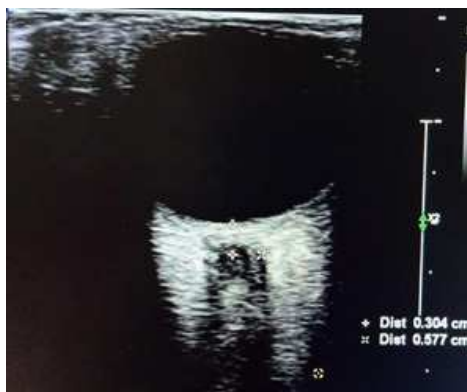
ONSD Ultrasonography right eye 1 hour post-operative with diameter 5,7 mm shows prediction of intracranial pressure > 20 mmHg
